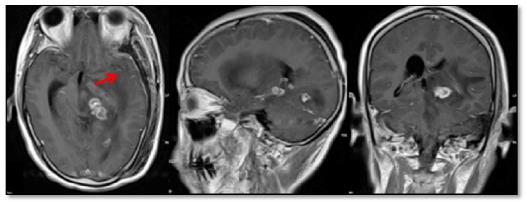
Post-operative MRI scan showed the left temporosphenoidlobe lesion had been resected.
